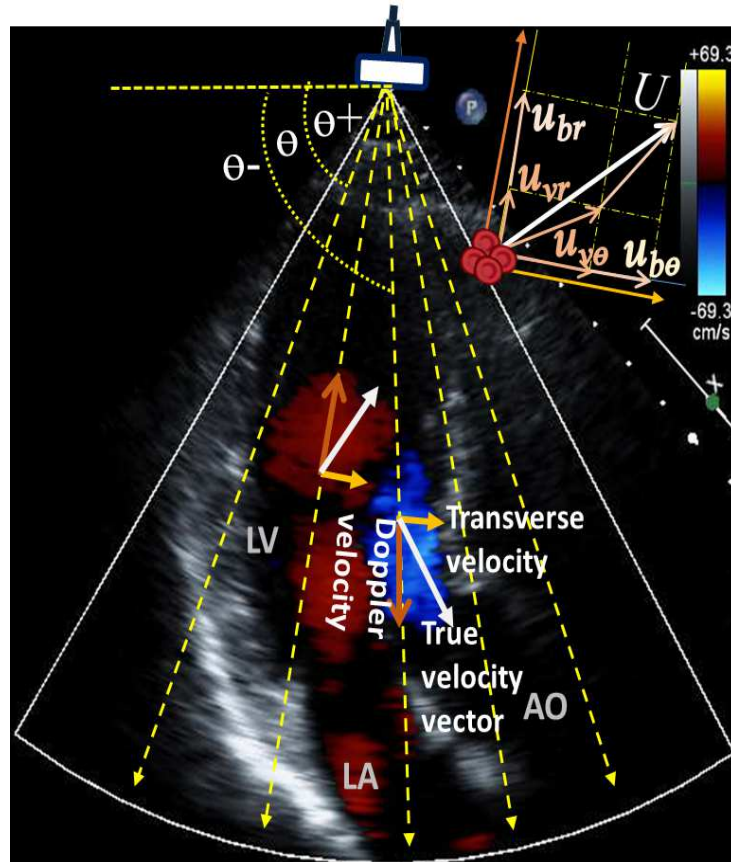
Apical three-chamber (A3C) view of the EDG method estimates the component of flow velocity in a perpendicular direction. The u_r Doppler velocity at a certain point is the projection velocity along the ultrasound beam. The component of the vortex flow of the longitudinal velocity u_{vr} and the transverse velocity of $u_{v\theta}$ forms the vector of vortex flow component. Likewise, the base flow component of longitudinal velocity u_{br} and transverse velocity $u_{b\theta}$ forms a flow vector of the base flow component. The true flow vector U is calculated by the sum of base u_b and vortex flow u_v components.
